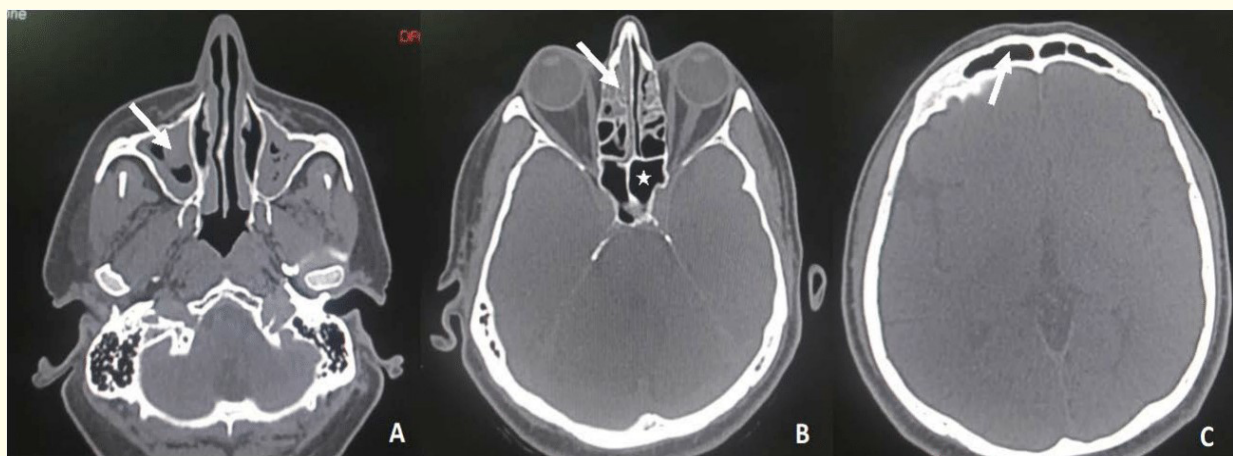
Axial cut CT-scans evaluating the facial sinuses. (A) Level of maxillary sinuses, showing bilateral maxillary mucosal thickening (arrow). (B) Level of ethmoidal and sphenoidal sinuses, showing bilateral mucosal thickening in both anterior ethmoidal air cells (arrow); the sphenoid sinuses are patent (star). (C) Level of frontal sinuses, normal appearance (arrow).
